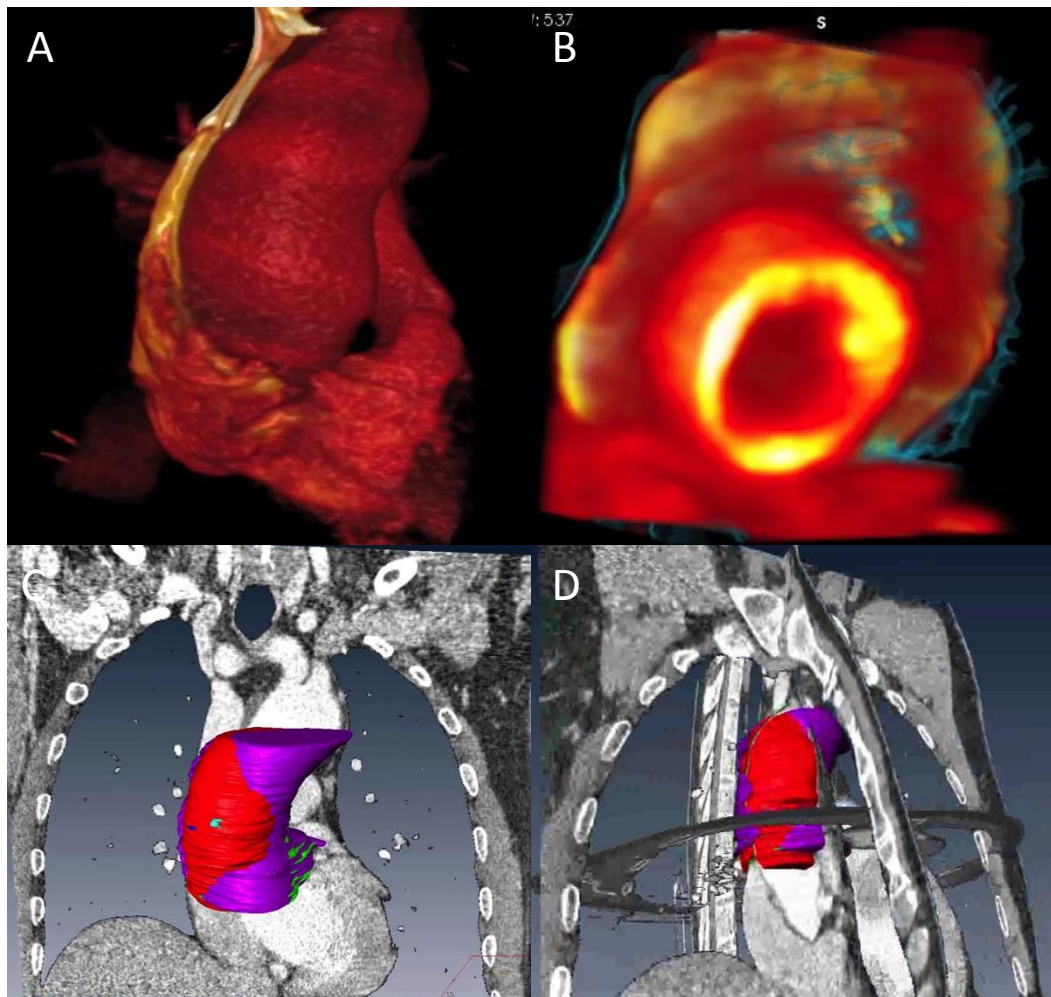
Image overlay of 3D fused PET-CT
